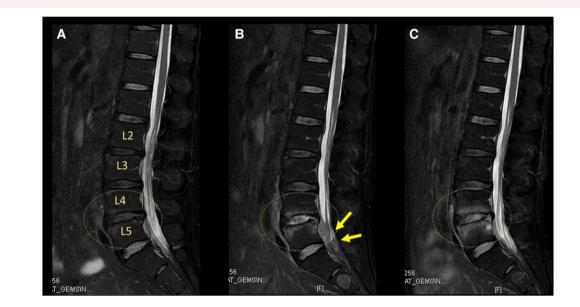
Magnetic resonance imaging findings. (A) On Day 1, no remarkable signs of infection are noted. (B) On Day 8, high signal intensity changes within the margins of the L4 and L5 vertebral bodies and the intervertebral disk on T_2 -weighted images are noted. Epidural abscess is also seen (arrows). (C) On Day 36, the epidural abscess has disappeared. The area of high signal intensity has expanded.
